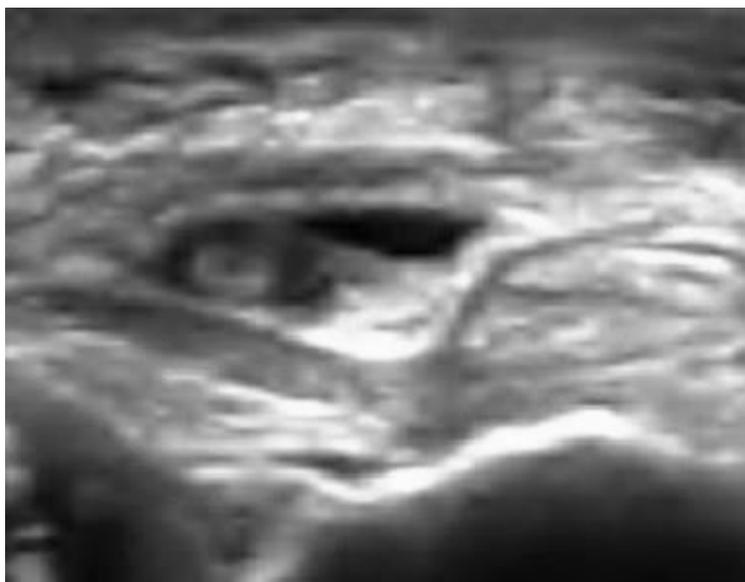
Transverse ultrasonographic scan of right tibialis posterior tendon partial tear with Tendosynovitis.
